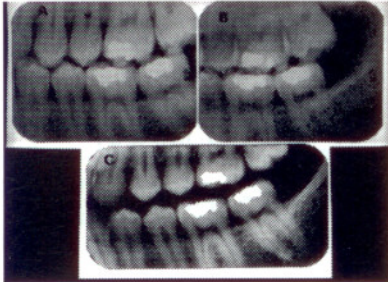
"Bite wing" radiographs of the left posterior teeth showing the morphology of the restorations in the molar teeth. A and B are antemortem and C postmortem radiographs.
